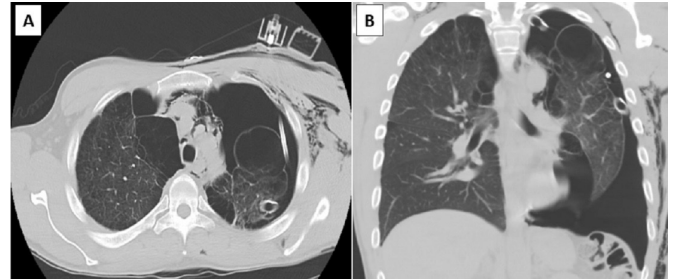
CT of the chest in axial (A) and coronal (B) views showing bilateral bullous emphysema in the lung apices. Persistent large left-sided pneumothorax, pneumomediastinum and subcutaneous emphysema were clearly evident.
